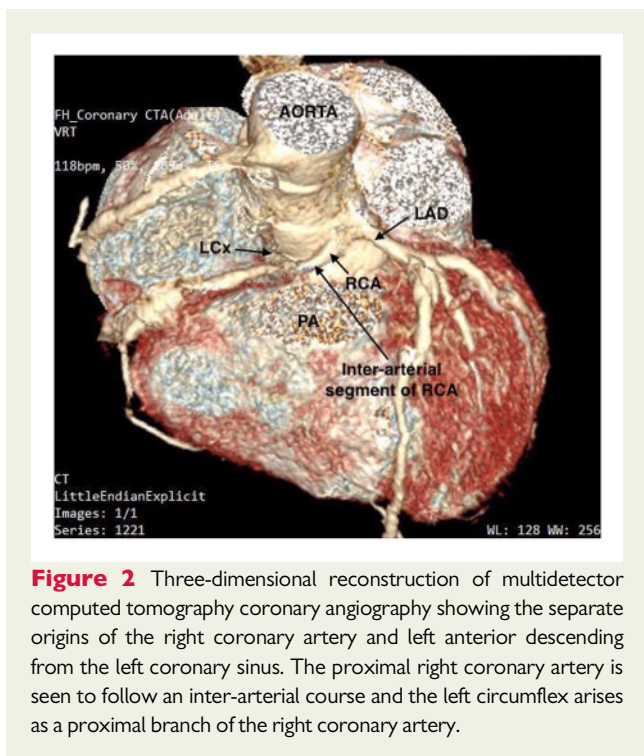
Three-dimensional reconstruction of multidetector computed tomography coronary angiography showing the separate origins of the right coronary artery and left anterior descending from the left coronary sinus. The proximal right coronary artery is seen to follow an inter-arterial course and the left circumflex arises as a proximal branch of the right coronary artery.
